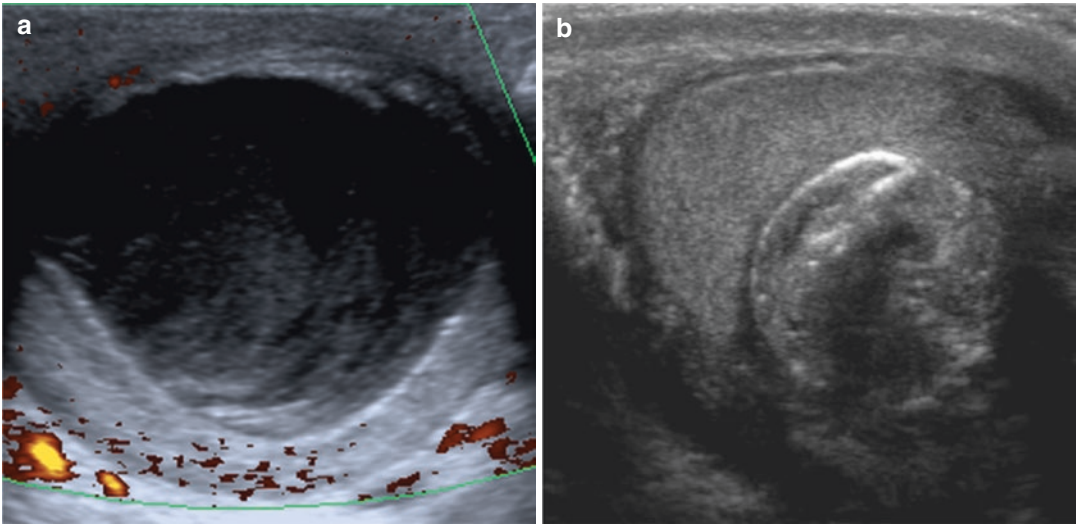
Epidermoid cysts. (a) The lesion is avascular at color Doppler interrogation. It shows thin wall and relatively echogenic content with onion-ring appearance. (b)
